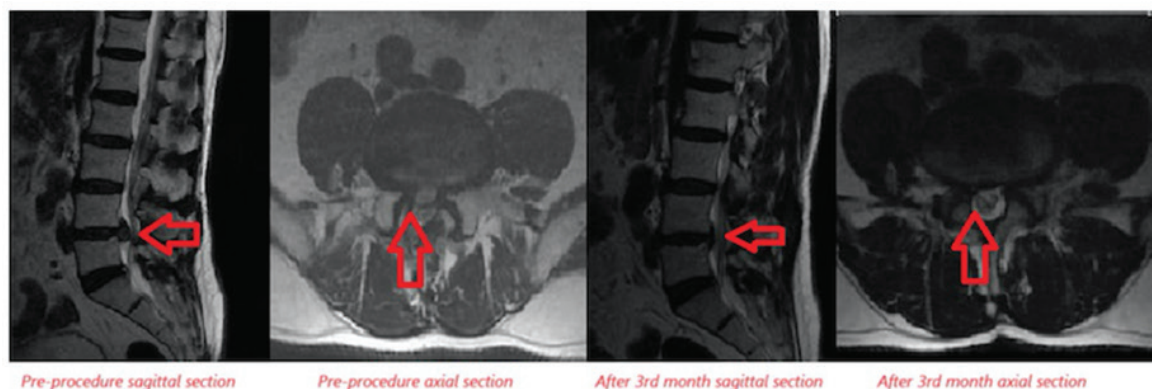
Examination of disc size reduction after ozone therapy in lumbar MRI sagittal and axial sections.
